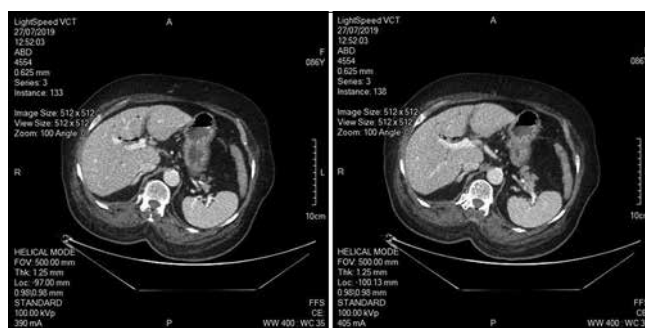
Multidetector computed tomography with contrast showed a hypodense lesion measuring 68 mm × 52 mm adjacent to gastric antrum and duodenum
